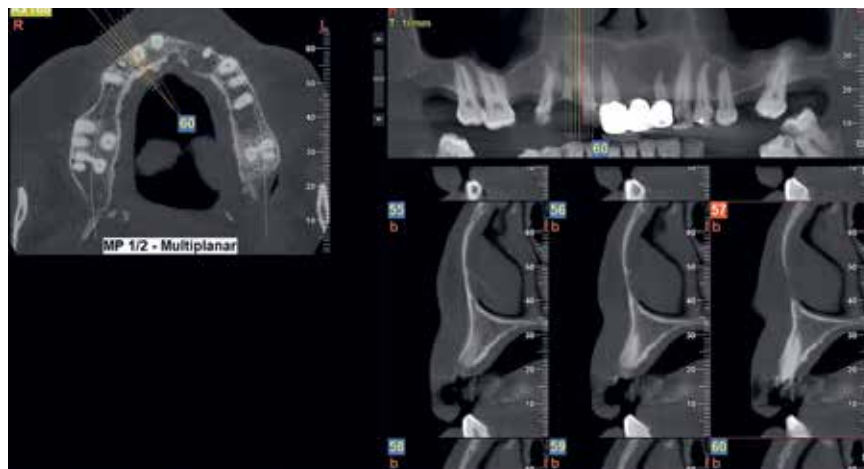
Very popular reconstruction layout for CBCT data visualization: Axial section (*left*) with a curved line indicating the panoramic reconstruction (*top right*) and a series of cross-sectional images (*bottom right*) perpendicular to the panoramic curved line.
